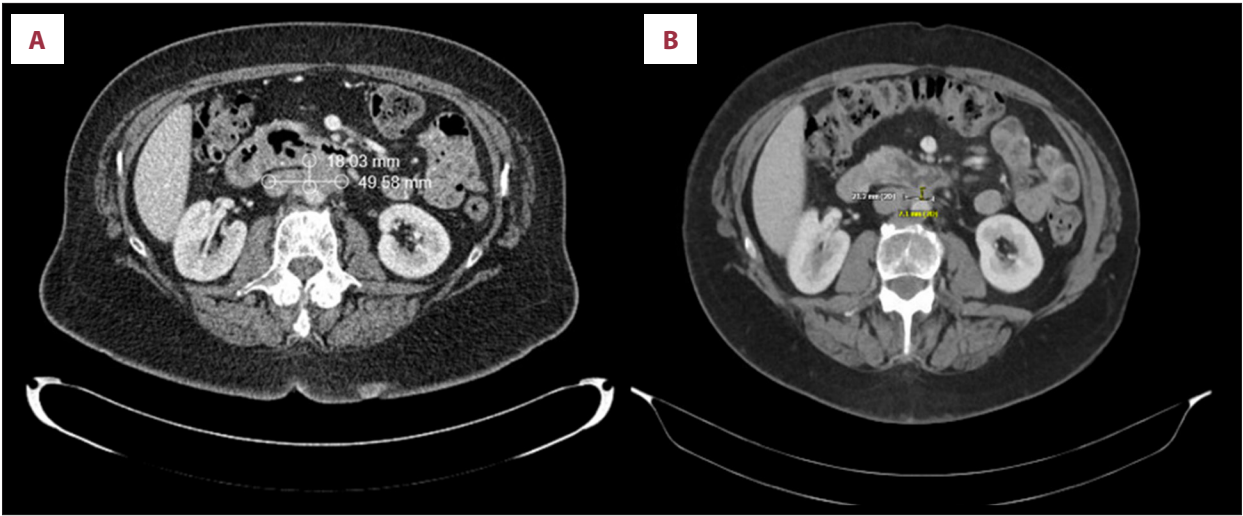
(A) Abdomen demonstrating 18.03×49.58 mm ill-defined retroperitoneal mass with invasion of the posterior third portion of the duodenum before the initiation of Pembrolizumab. (B) CT abdomen shows interval decrease ill-defined retroperitoneal mass size from 18.03×49.58 mm to 7.2×21.2 after 6 months of treatment with pembrolizumab.
